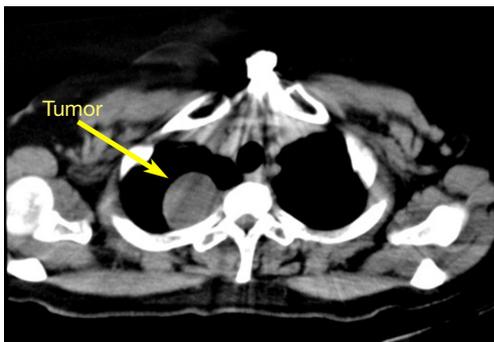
Chest CT shows a mass in the in the right posterior superior mediastinum.
